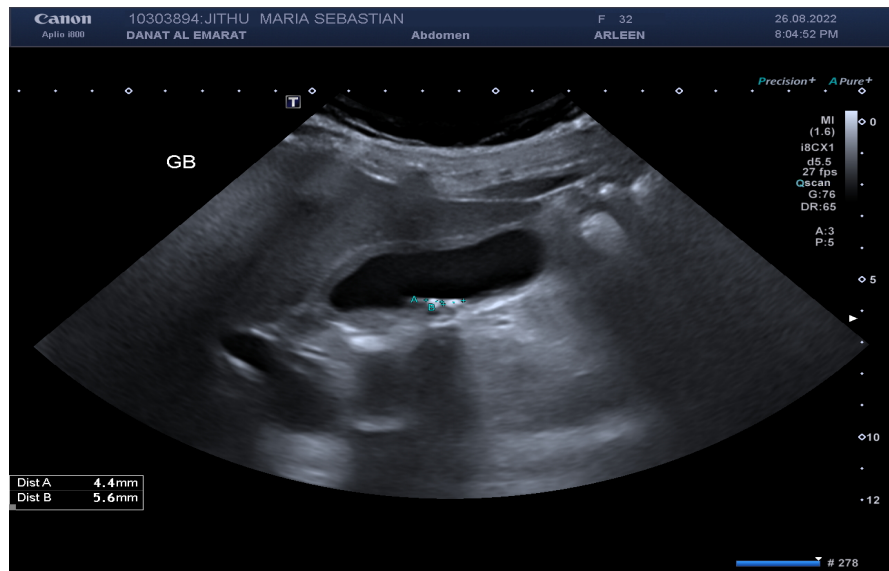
Images of ultrasound of gall bladder.
